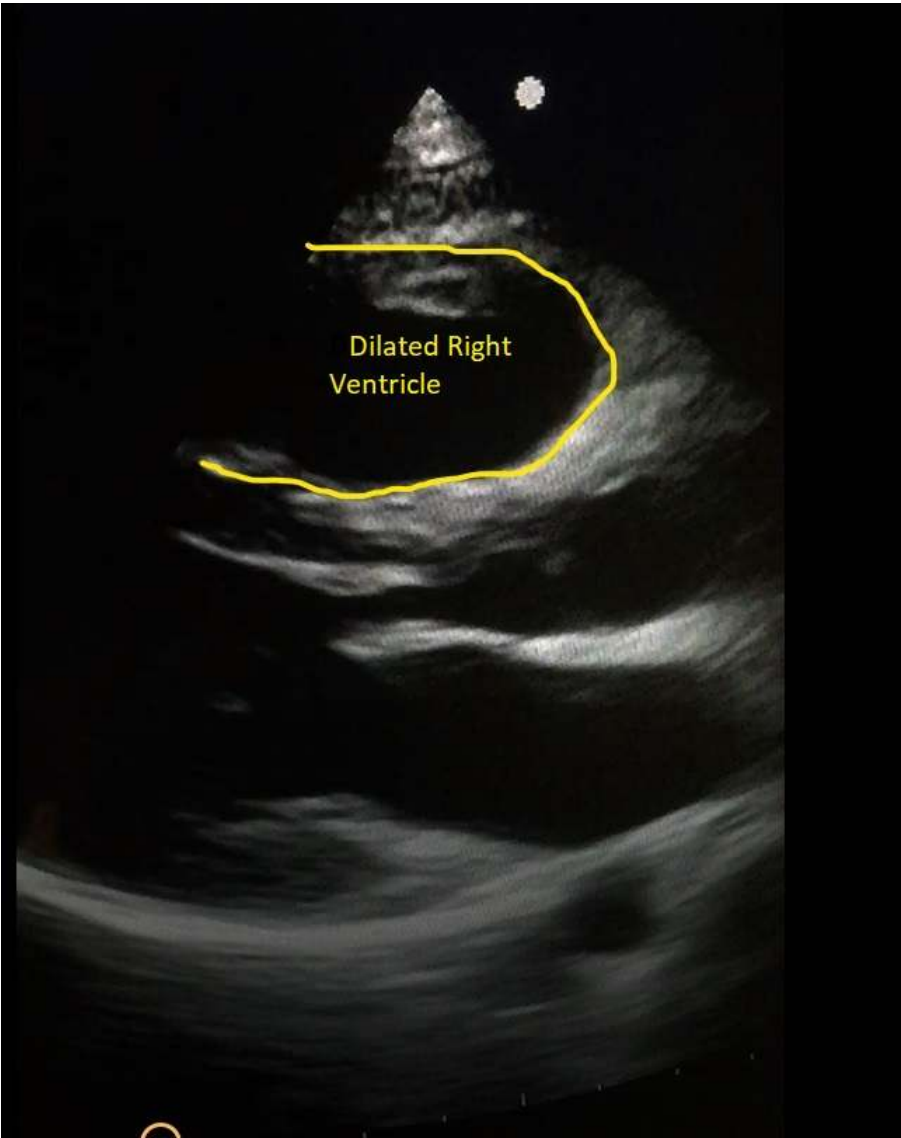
Apical 4 chamber view showing dilated right ventricle compared to left ventricle
